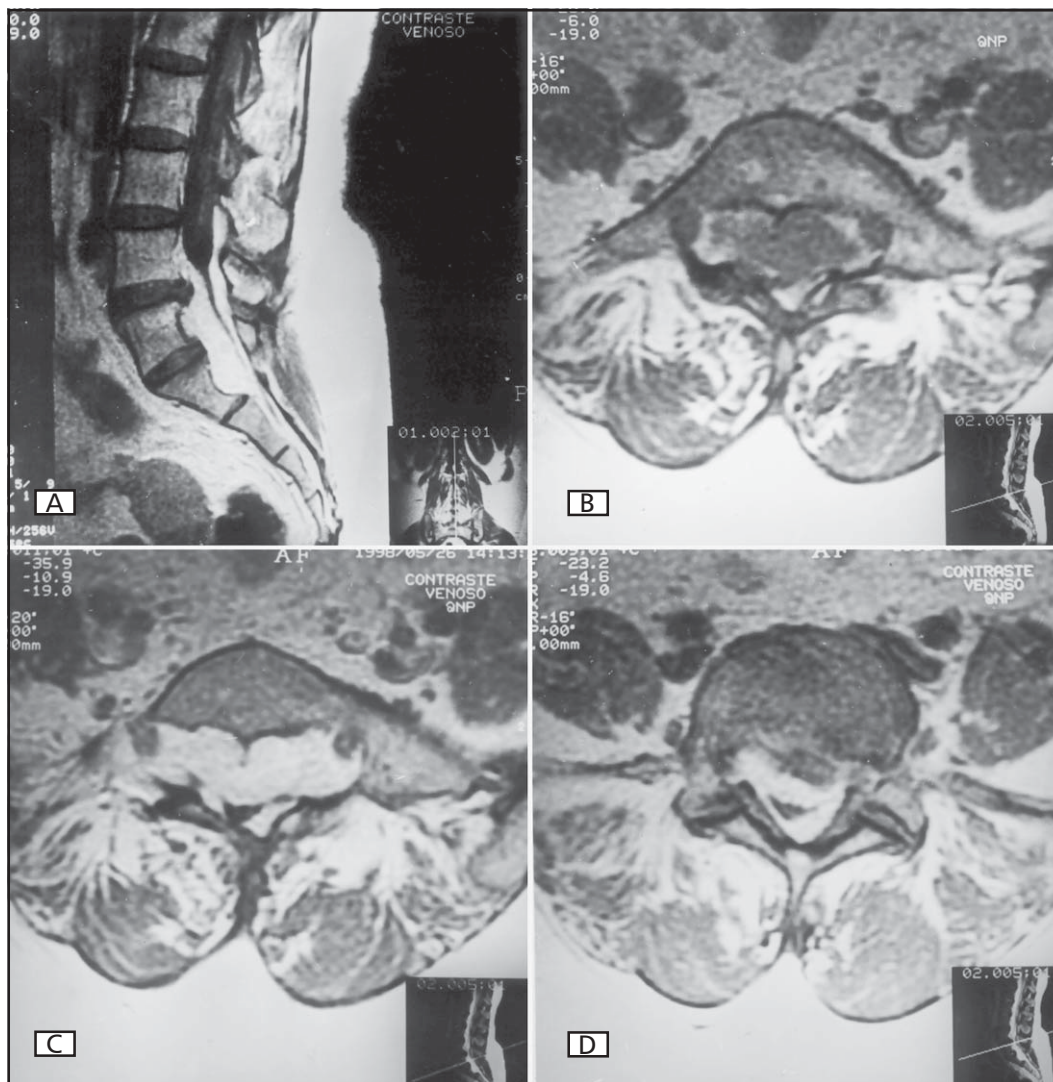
Preoperative MRI scans. A, sagittal T1-weighted scan with gadolinium infusion of the lumbosacral spine showing a ventral mass from L4 to S2 with homogeneous contrast enhancement. B, axial T1-weighted scan, without contrast at the S1 level. C, axial T1-weighted scan with contrast showing erosion of the sacrum and extension of the tumor to the sacral foramina. D, axial T1-weighted scan displaying the upper limit of the tumor associated with a lumbar disc herniation at L4-L5 level.
